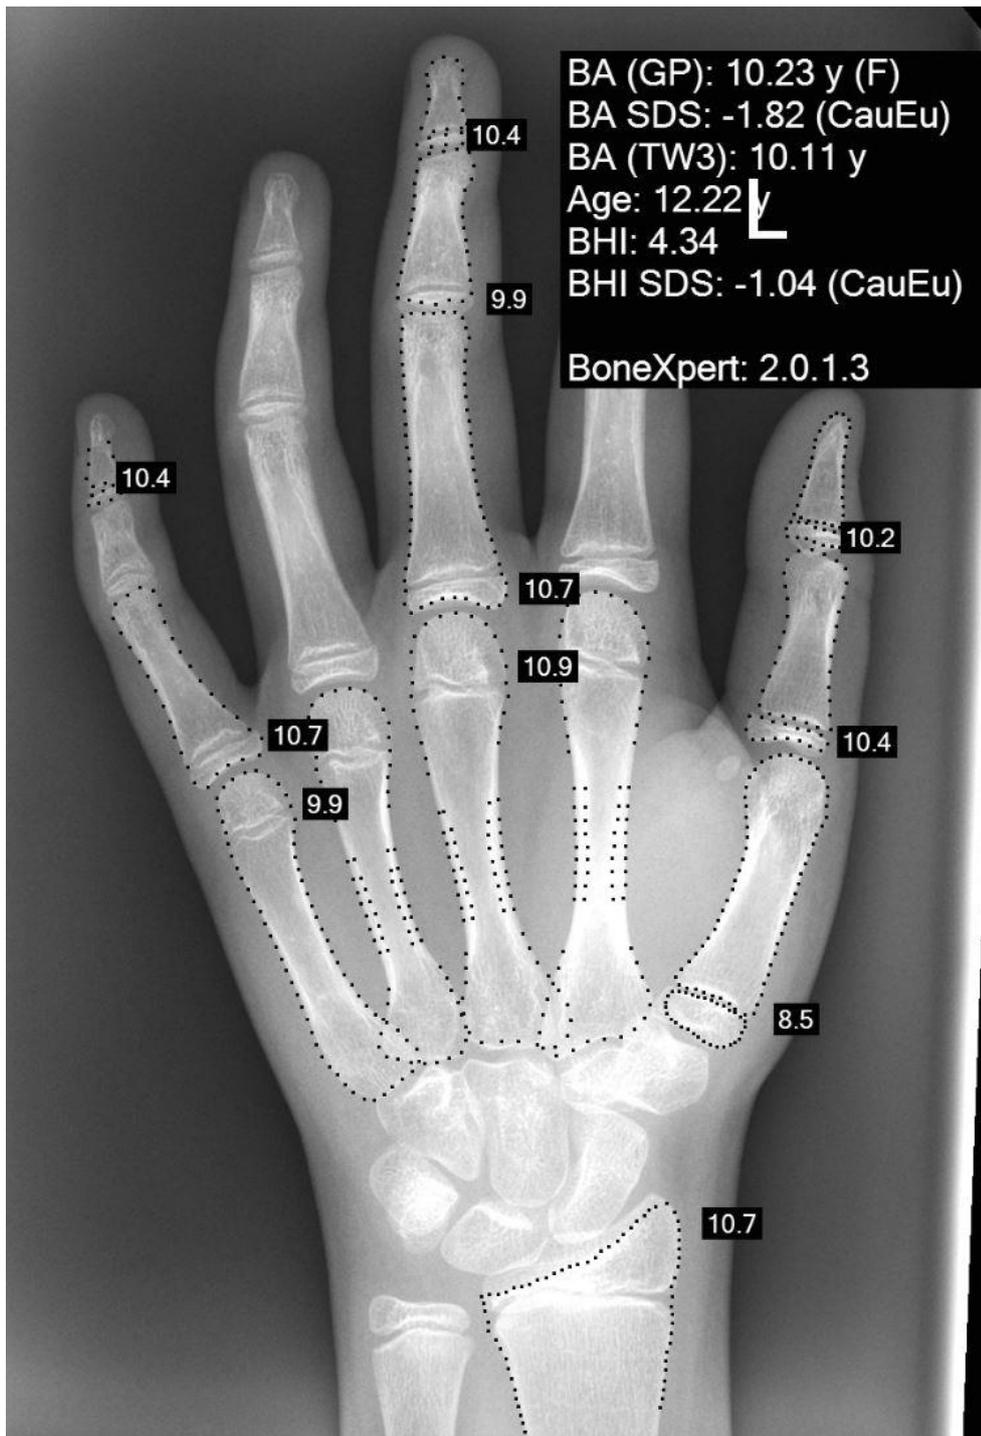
BoneXpert reading of the left-hand radiograph of a 12-year-old female. BA (GP); Greulich and Pyle bone age. SDS; standard deviation score. CauEu; Caucasian, European. TW3; Tanner and Whitehouse 3. BHI; bone health index.
